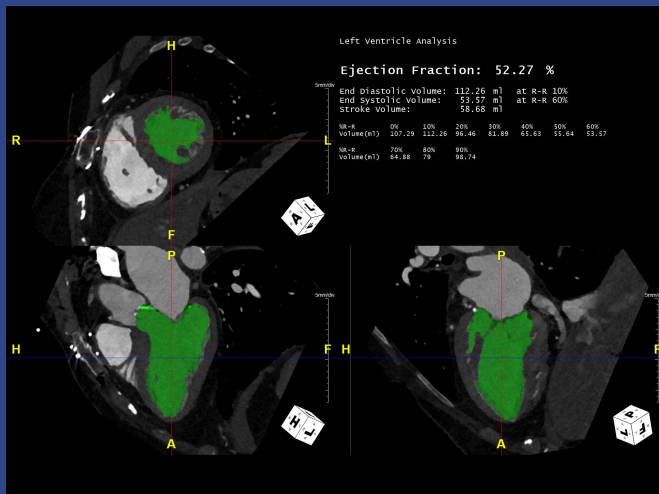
CT image from author's clinical collection, de-identified (M.Trump, 2025)
